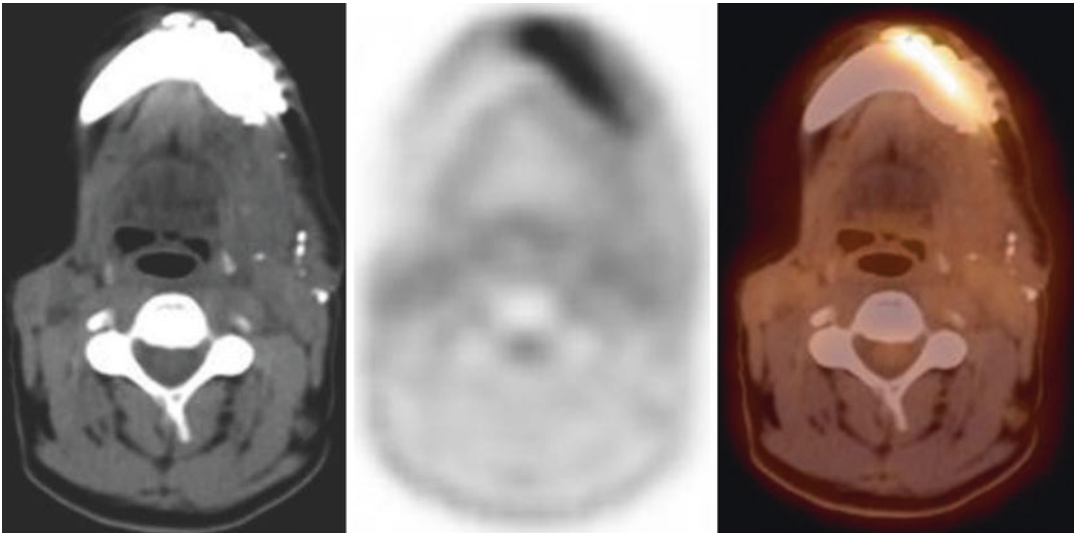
A 49-year-old male with a history of squamous cell carcinoma of the floor of the mouth and alveolar ridge, status post left marginal mandibulectomy and bilateral supraomohyoid neck dissection. PET/CT images
